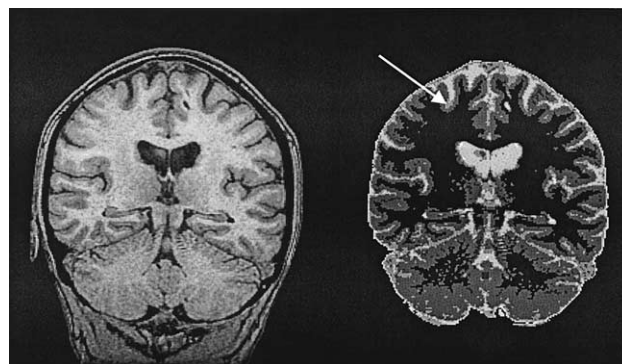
Left image is a T1-weighted coronal slice from a posttraumatic stress disorder patient. Right image shows the segmentation of extracted brain into white matter, gray matter, cerebrospinal fluid (CSF), and gray matter/CSF partial volume (arrow).
